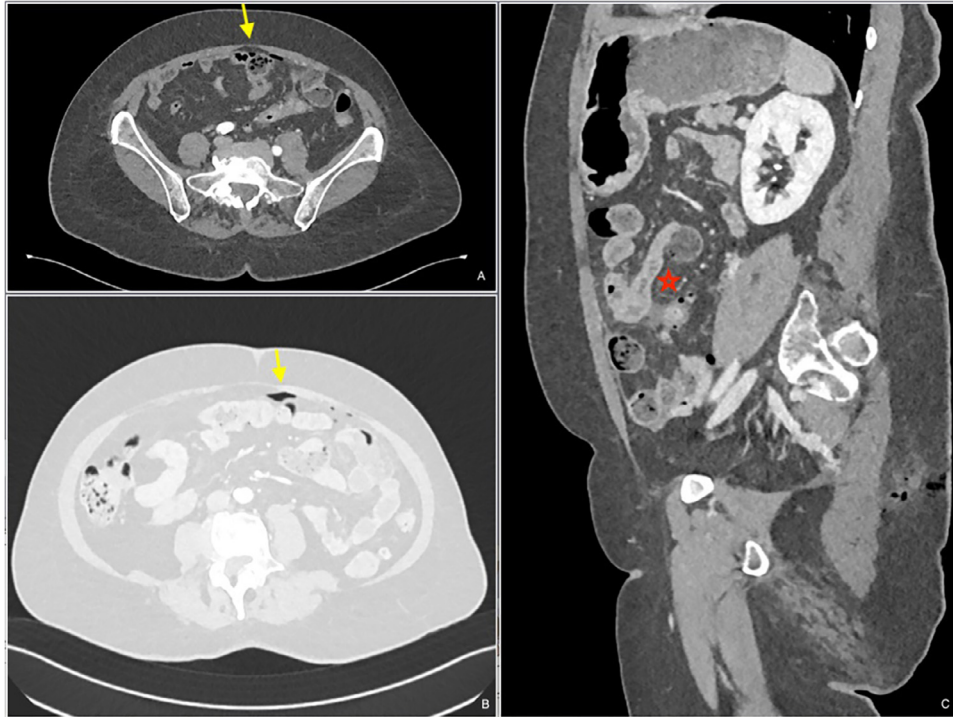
(A-C). Axial (an arterial phase, [B] lung window) and sagittal (c) CT images. Small air bubbles (yellow arrows) were detected close to anterior peritoneal reflection. An hyperdense pocket of fluid was appreciated close to a small bowel loop (star). Findings were diagnostic of bowel perforation.
